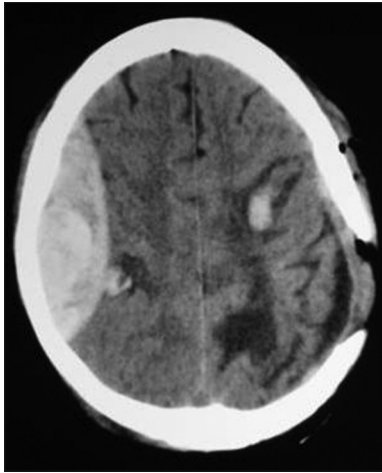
Axial CT scan of brain taken two days after evacuation of first EDH showing, new EDH over contralateral side
